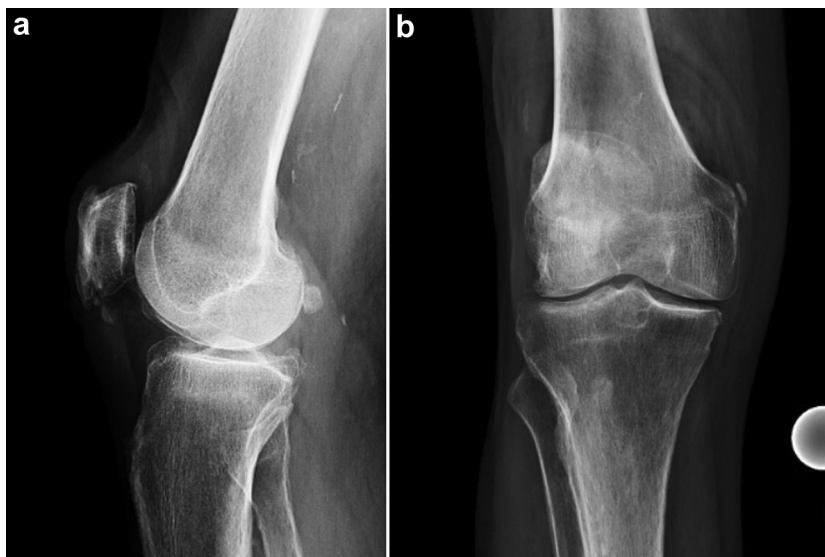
Preoperative AP (a) and lateral (b) radiographs from patient 1 displaying tricompartmental osteoarthritis of the right knee.
